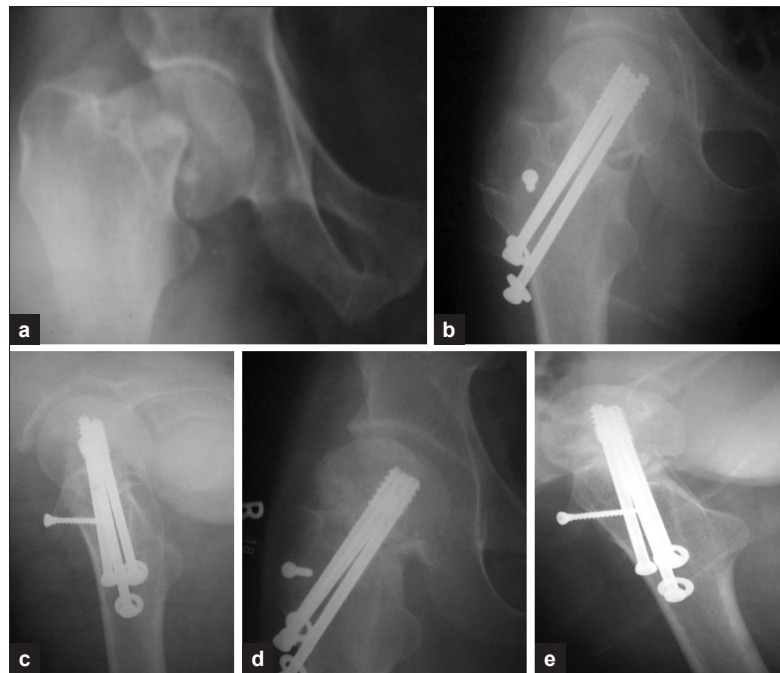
(a) X-ray right hip joint (anteroposterior view) showing ununited femoral neck fracture (b) postoperative X-ray (anteroposterior view) showing valgoid reduction, screws in position (c) postoperative x-ray (lateral view) showing position of screws (d) 2.3 years followup (anteroposterior view) showing fracture union (e) 2.3 years followup (lateral view) showing fracture union
